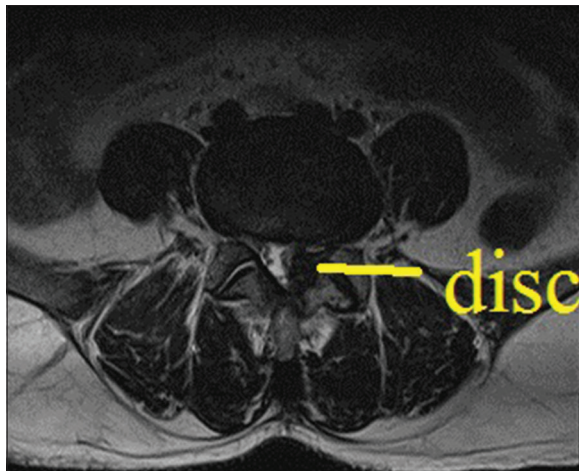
Axial magnetic resonance imaging sequestered posterior epidural lumbar disc
